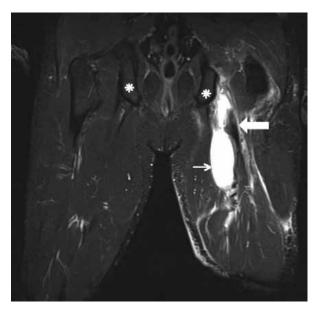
Coronal plane MRI image of typical acute avulsion of left hamstrings. Hematoma (small arrow) and the retracted tendon-head (big arrow) are seen. Asterisk marks the ischial tuberosities on both sides.
